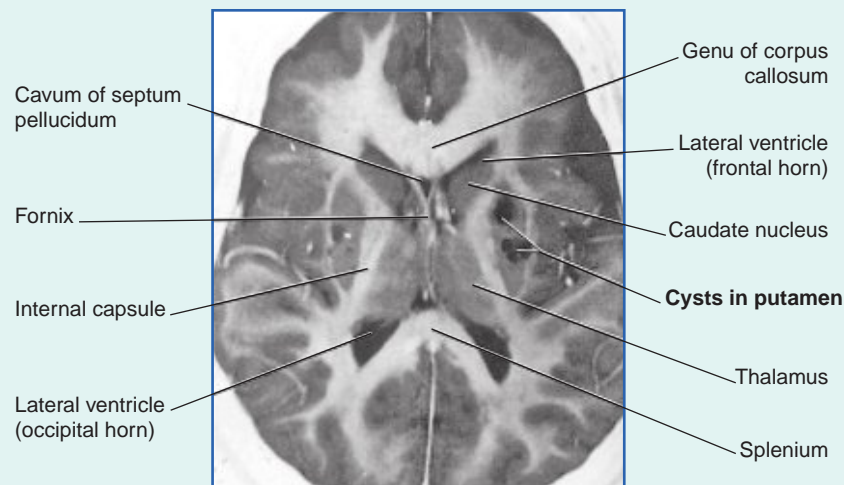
Horizontal magnetic resonance imaging (MRI) slice at the level of the corpus striatum from a 2-year-old girl suffering from severe choreoathetosis as a result of intrauterine damage to her basal ganglia by toxoplasmosis. The putamen on both sides has been partly replaced by cysts. (MRI kindly provided by Professor J. Paul Finn, Director, Magnetic Resonance Research, Department of Radiology, David Geffen School of Medicine, UCLA, California, USA.)
